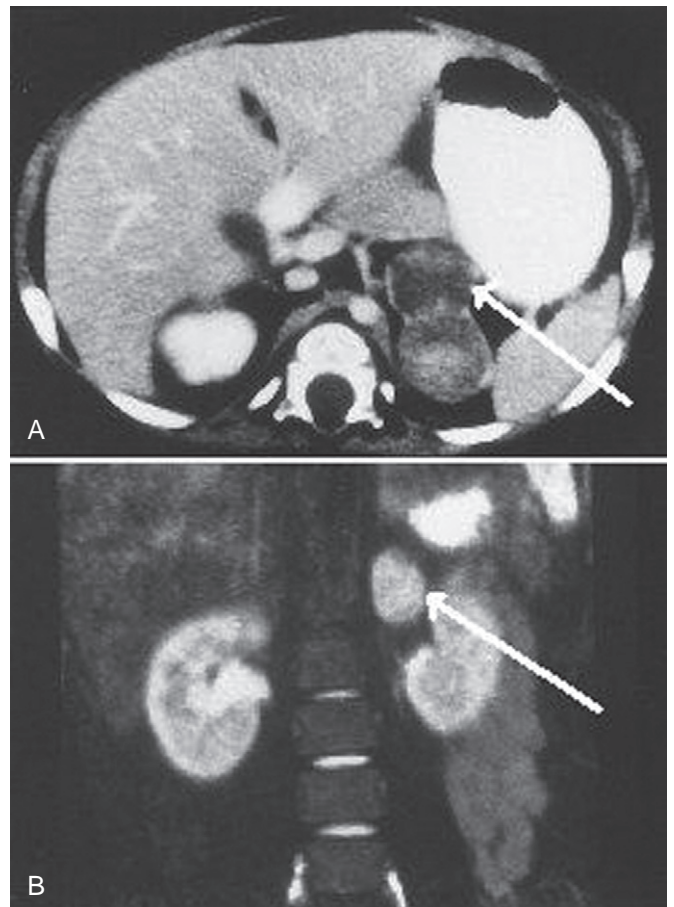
A, Computed tomography of the abdomen in a 10-year-old girl with a left adrenal mass associated with hypertension. B, Magnetic resonance image demonstrates a left adrenal pheochromocytoma. No other masses were noted. No contrast agent was required.
